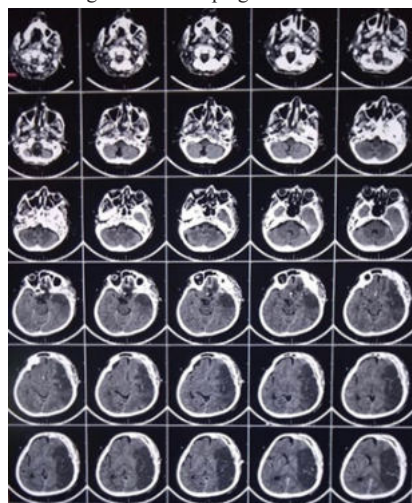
Computed tomography head scan done on the third postoperative day showing a left MCA infarct with mass effect
